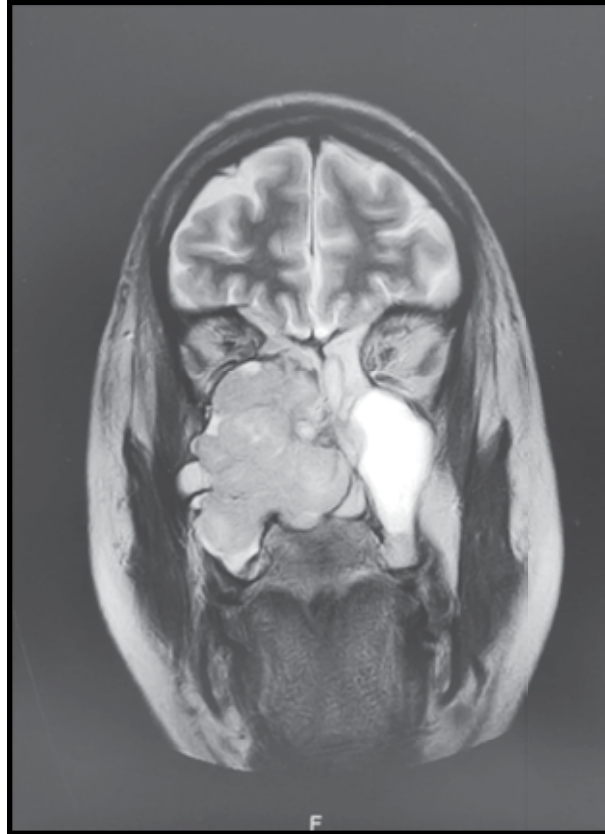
MRI showing mass lesion extension into the maxillary sinus
